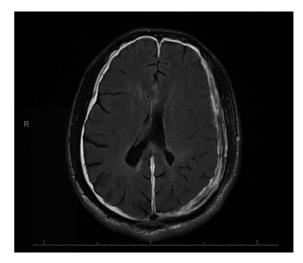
MRI of the brain reveals a left recollection of subdural hematoma. Axial T2-MRI of the brain showed a left holohemispheric subdural hypointense hematoma measuring about 1.9 cm in maximum depth with midline shift measuring about 0.3 cm. MRI, magnetic resonance imaging.
